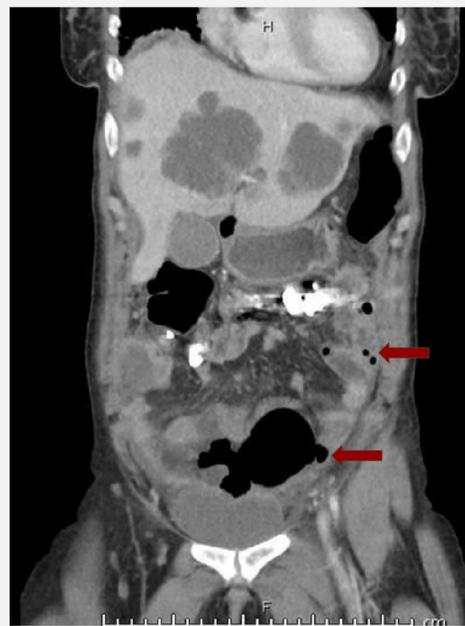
Coronal view CT Abdomen and pelvis with contrast with evidence of intra-abdominal gas and presence of hepatic abscesses
